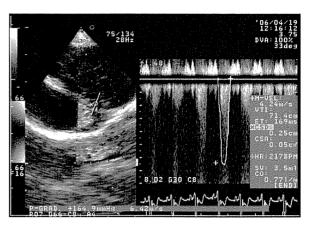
Echocardiography of right ventricular outflow tract. Pulmonary arterial flow velocity of 6.42 m/second was observed on 68 days, corresponding to a pressure gradient of 164.9 mmHg.
